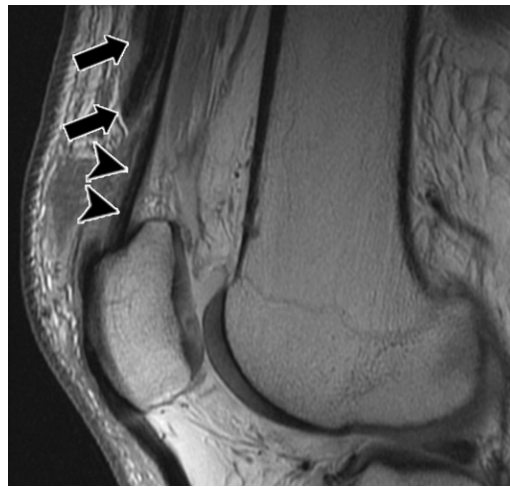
Partial tear of the quadriceps tendon in an 81-year-old man with ecchymosis, knee pain, and a sense of instability after jumping a few inches off a curb. Sagittal PD-weighted MR image shows a partial tear of the quadriceps tendon. The rectus femoris, vastus medialis, and vastus lateralis tendons are torn and proximally retracted (arrows). The vastus intermedius tendon (arrowheads) at the posterior quadriceps remains intact, and patellar position is normal.
